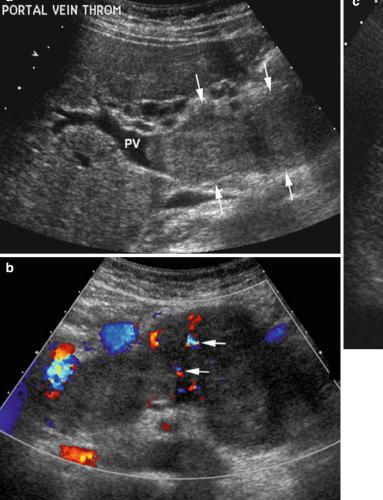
Tumor thrombus in portal vein. (a) Transverse view showing large tumor (arrows) expanding portal vein (PV). (b) Color Doppler of tumor in portal vein showing scattered blood flow (arrows) confirming
